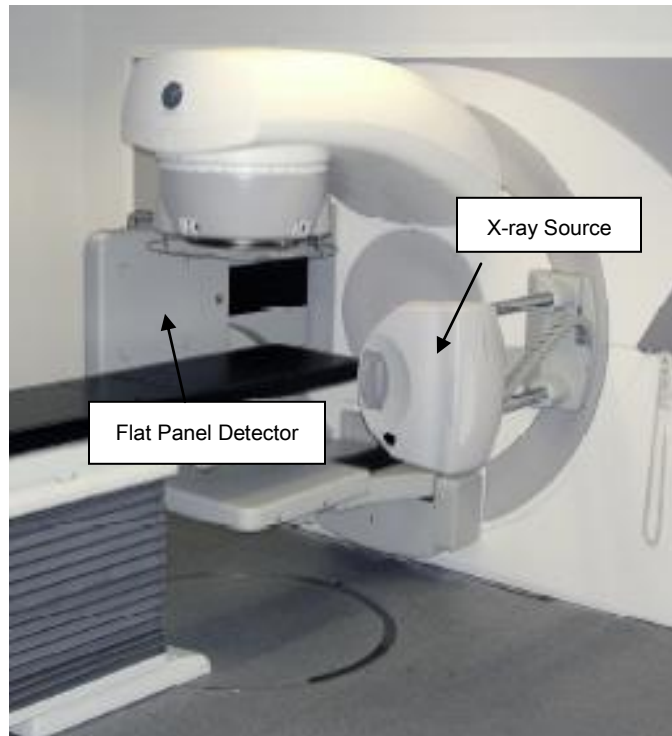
kV X-ray source and kV flat panel detector mounted isocentrically to the accelerator gantry (XVI, Elekta, Crawley, UK).² (Photo courtesy of Elekta, Stockholm, Sweden)
